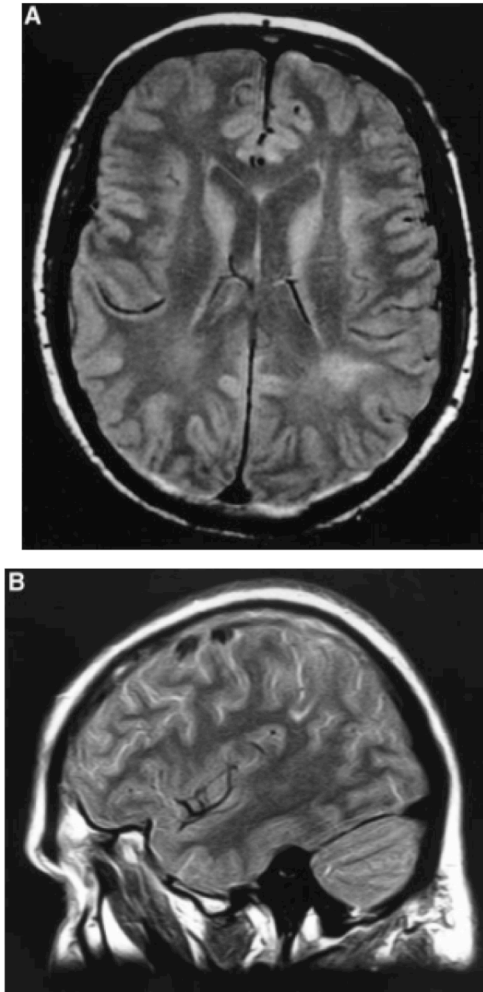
Mayer et al. experiment, (1999)*. MRI axial (A) and sagittal (B) sections of H.P.'s brain showing the left subangular ischaemia.
